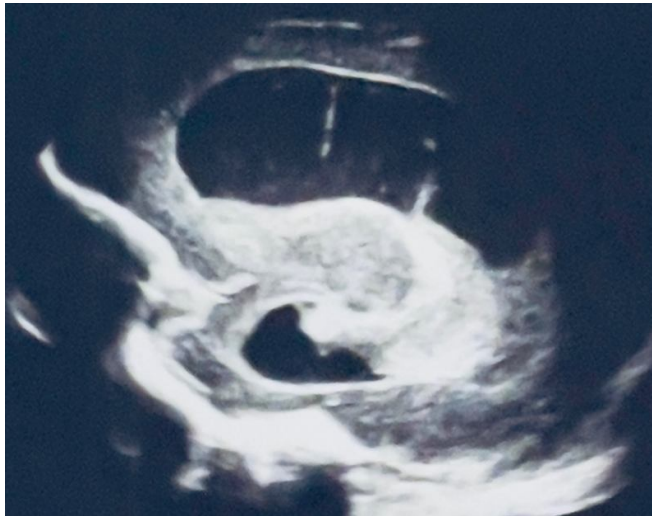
TRANSFONTANELLAR ULTRASOUND SAGITAL SECTION
